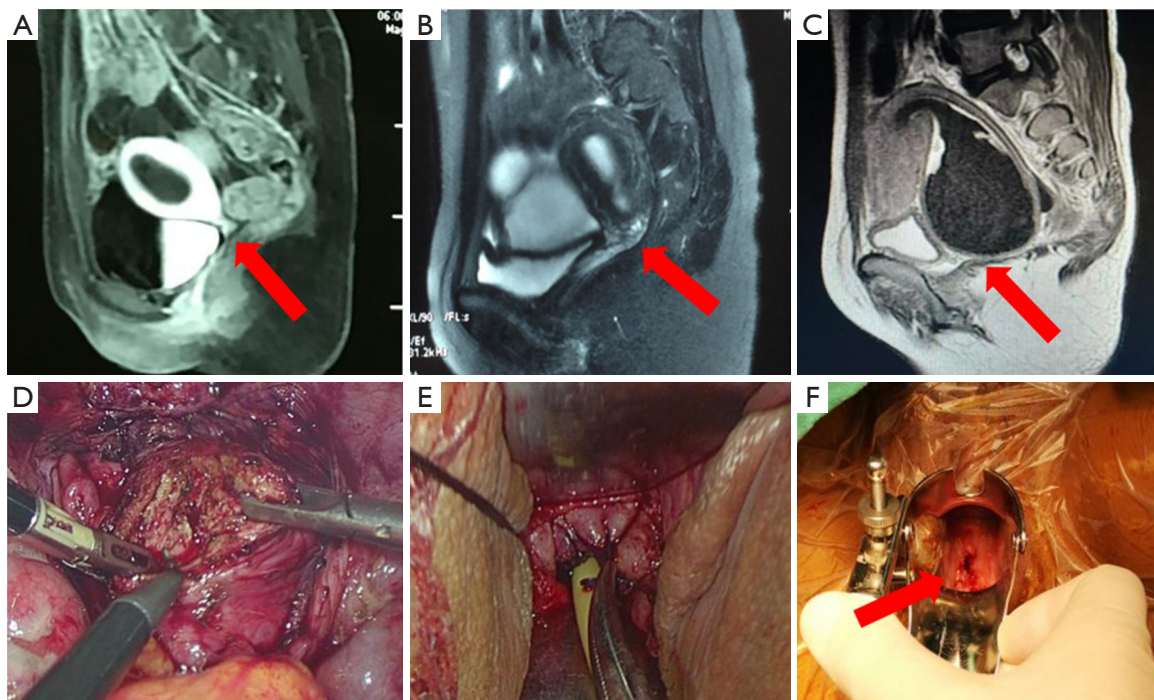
MRI image of a vagina and uterus and the surgical procedure for patients with congenital cervical and complete vaginal atresia. (A) Type A cervical atresia: cervical dysplasia accompanied by hematometra; the red arrow indicates atresia of the cervix. (B) Type B cervical atresia: hematometra concurrent with stenosis, effusion, and partial atresia of the cervical duct; the red arrow indicates atresia of the cervix. (C) Type C cervical atresia: a normal uterus and cervix, with the inferior uterine segment and the cervix being obviously dilated and showing effusion; the red arrow indicates atresia of the cervix. (D) The orifice of the cervix is laparoscopically dissected in the shape of a plus sign, and a No. 12 (millimeters' width) dilator rod is inserted through the cervical orifice. (E) The cervix is pulled down into the neovaginal cavity to form a “vaginal vault”, and the apical vagina is sutured with the superior cervical segment. (F) In one patient, the cervical orifice appeared normal, and the “vaginal vault” disappeared 1 year after the surgery; the red arrow indicates the artificial neocervix. MRI, magnetic resonance imaging.
